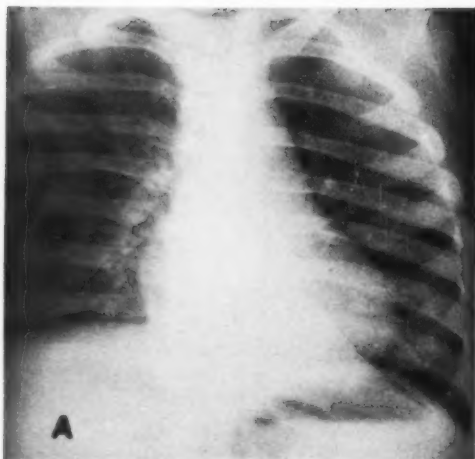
Case IV, in child of four years. Atelectasis and bronchiectasis of left lower lobe. A. Chest roentgenogram. B. Bronchogram.
